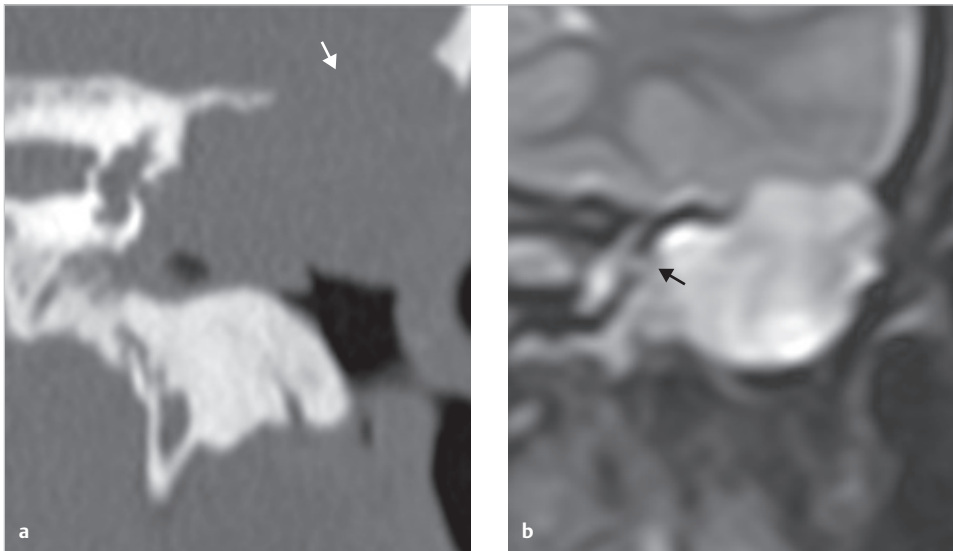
The coronal CT shows presence of massive soft tissue superiorly to the external auditory canal (a). The middle fossa dura is widely exposed (white arrow), and the superior bony wall of the meatus is lost. The T2-weighted image of MRI demonstrates high signal, corresponding to cholesteatoma (b). Presence of labyrinthine fistula in the lateral semicircular canal is demonstrated in the MRI (black arrow).
